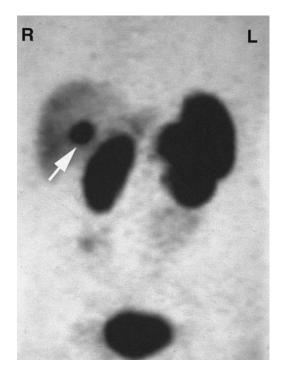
Another somatostatin receptor scintigram showing a metastatic gastrinoma in the liver (*white arrow*). Again, the enhancing area on the right of the figure is the spleen.
